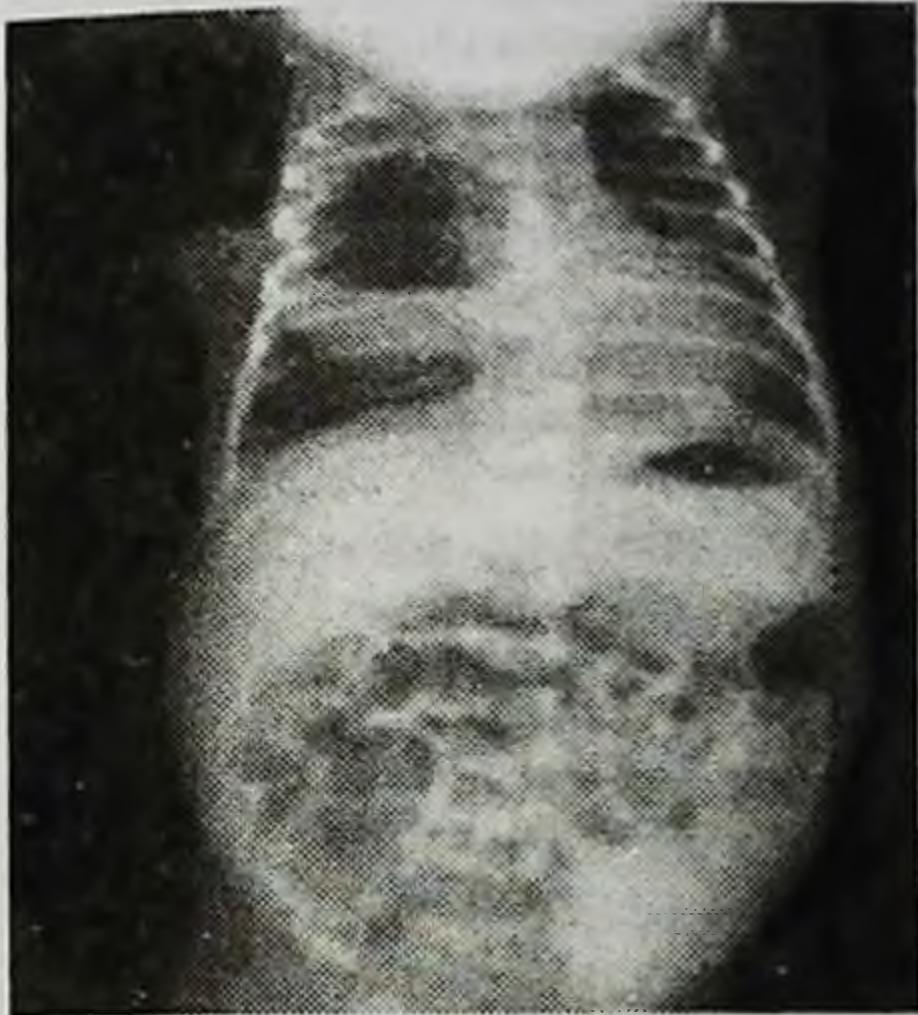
On the radiograph, a bronchogenic cyst on the right
